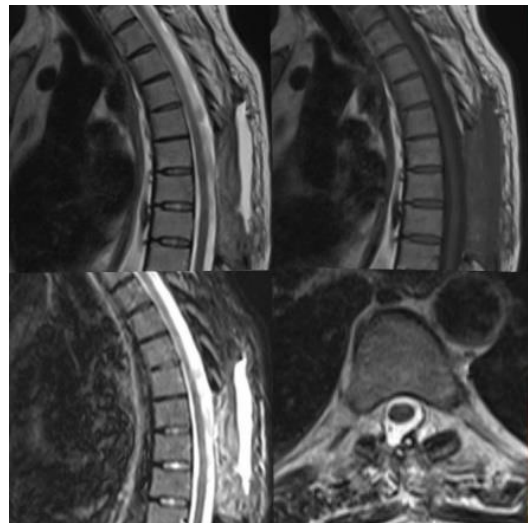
Thoracic MRI scan at 1 month postoperatively shows complete excision of the extradural mass and recovery of the spinal cord.
